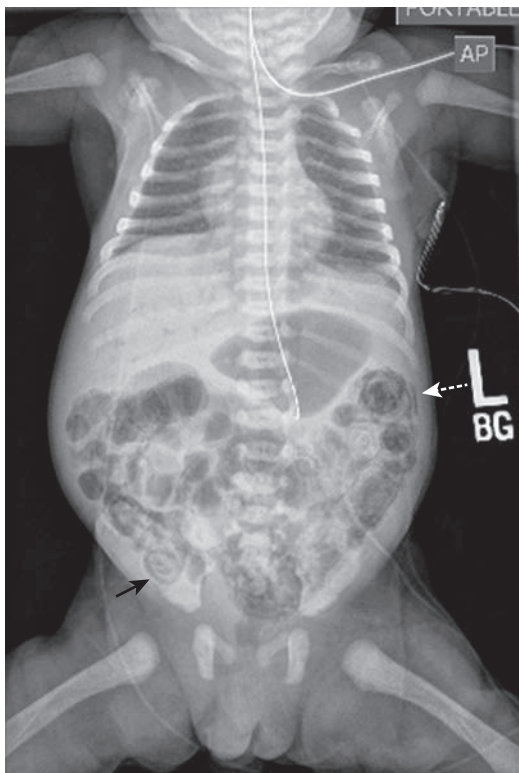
Pneumatosis intestinalis is the classic radiographic finding in NEC. The air within the bowel wall may be cystic (solid arrow) or linear (dotted arrow) on the abdominal film, and may be seen in a focal intestinal segment or diffusely throughout the bowel as is visualized on this abdominal film.
